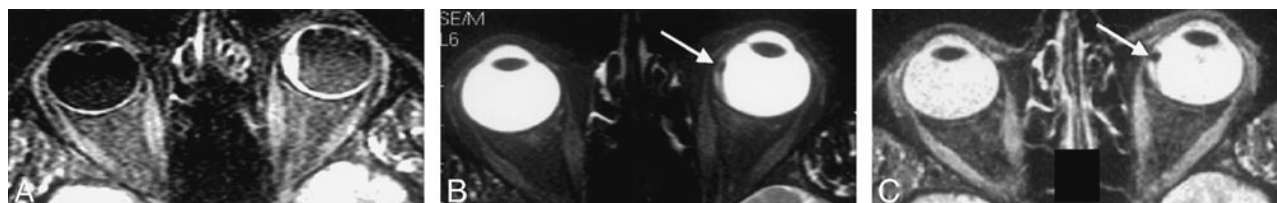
Axial images through the globe in a patient with a small melanotic melanoma with an associated retinal detachment. The SPIR/FLAIR sequence (A) shows the extent of the detachment more clearly than the T2-weighted SPIR (B) and STIR images (C), but does not reveal the tumor itself.
